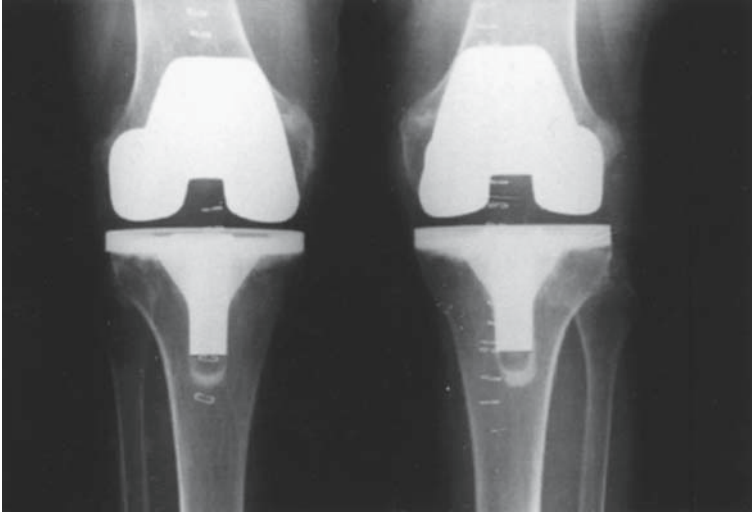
Standing AP radiograph of both knees 2 weeks after one-stage bilateral knee replacements in the 70-year-old female patient whose preoperative radiograph is shown in Figure 12-4.
